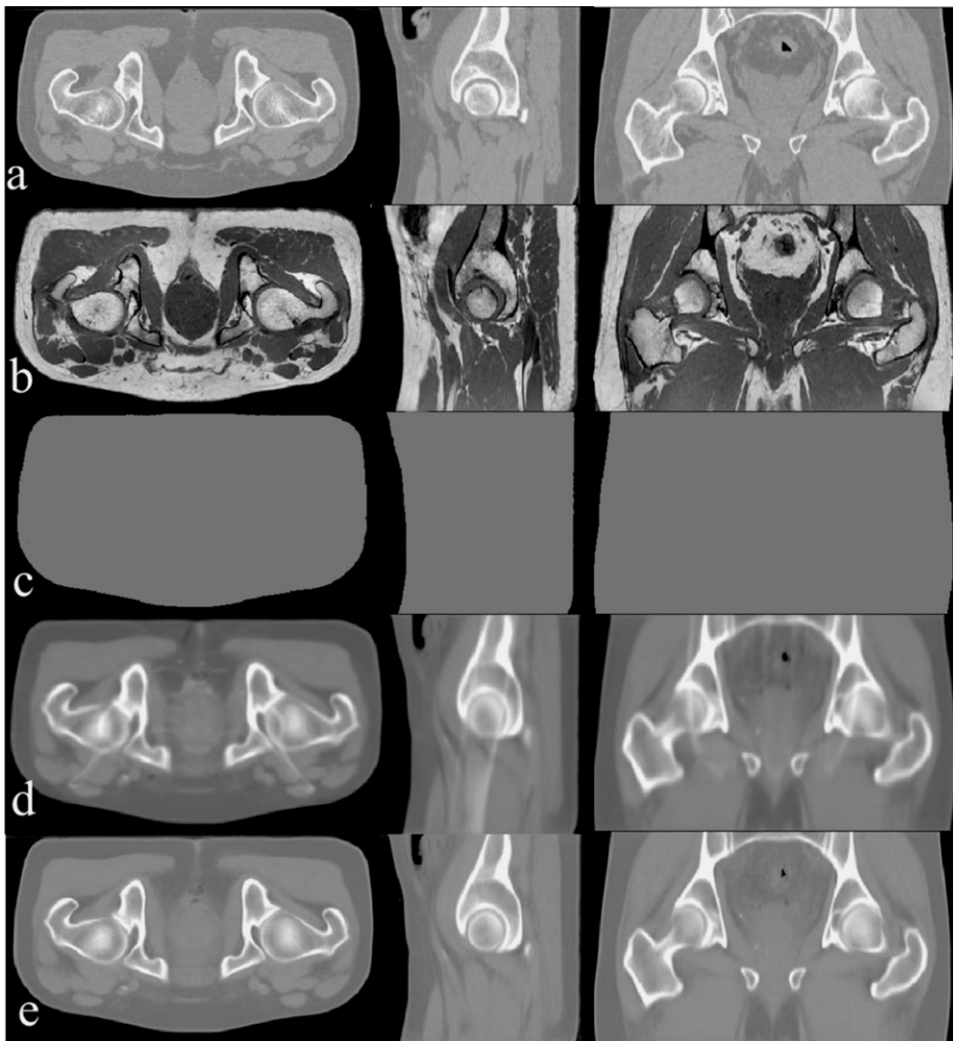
(a) Reference CT; (b) target MRI; (c) water-only μ -map; (d) pseudo-CT generated using the MV technique; (e) pseudo-CT generated using the LW atlas fusion method.
